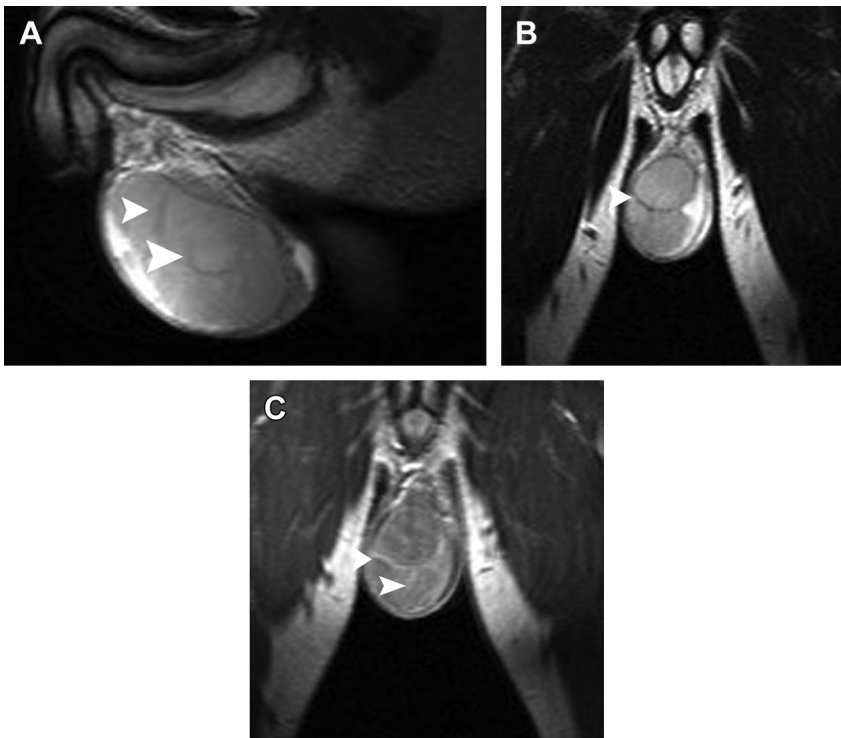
Typical right testicular seminoma, confined to the testis. Sagittal (A) and coronal (B) T2-weighted images show multinodular right intratesticular mass. The tumor is mainly hypointense on T2-weighted images, with thin hypointense septa (arrowheads). (C) Coronal postcontrast T1-weighted image shows enhancement of tumor septa (arrowheads). Imaging findings are suggestive of seminomatous tumor.
